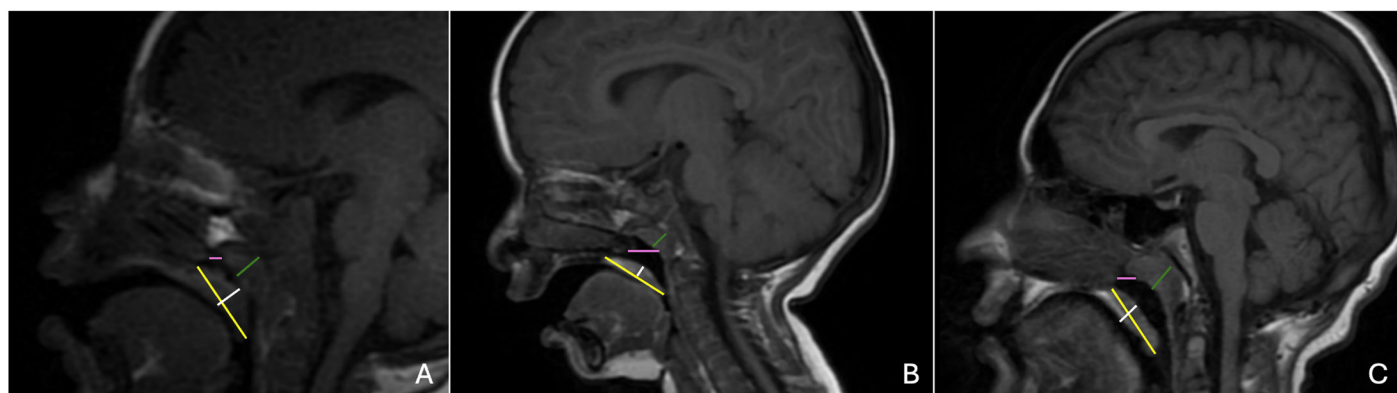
Sagittal T1 FLAIR magnetic resonance images of pediatric patients demonstrating morphometric parameters. (A) 1-year-old male, (B) 3-year-old male, and (C) 13-year-old male. Uvula width (white line) and height (yellow line), adenoid hypertrophy (green line), and nasopharyngeal airway distance from the posterior nasal spine to the posterior pharyngeal wall (pink line) are annotated
